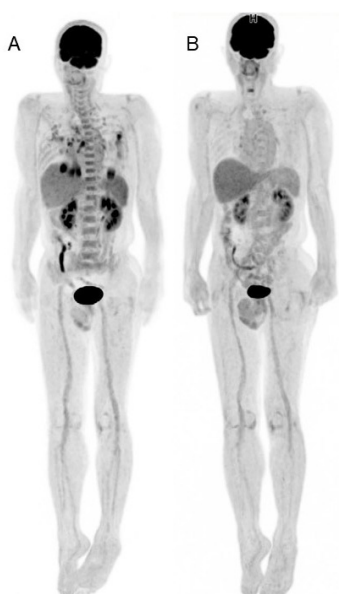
Whole-body FDG-PET images of COVID-19. (A): Whole body FDG-PET image of the patient with COVID-19 pneumonia (4 weeks after symptom onset and 3 weeks after negative RT-PCRs). (B): Whole-body FDG-PET image of the patient with COVID-19 pneumonia (4 weeks from previous FDG-PET scan). Intense FDG uptake was confirmed in lung lesion and mediastinal lymph node in the first image. In addition, increased FDG was seen in bone marrow and spleen. FDG uptake in lung lesion and mediastinal lymph node disappeared, and uptake in bone marrow and spleen were decreased as physiological uptake level.
